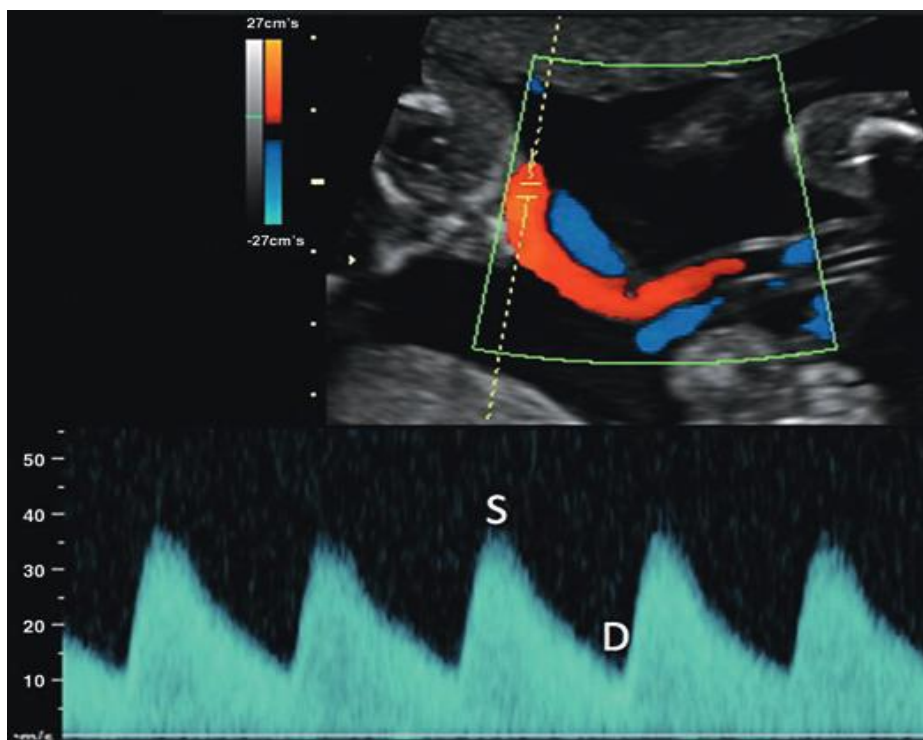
Doppler waveforms of the umbilical artery in a normal fetus in the third trimester of pregnancy. Note the increased end-diastolic velocity (D), consistent with a low impedance circulation. (S) peak systolic velocity.
